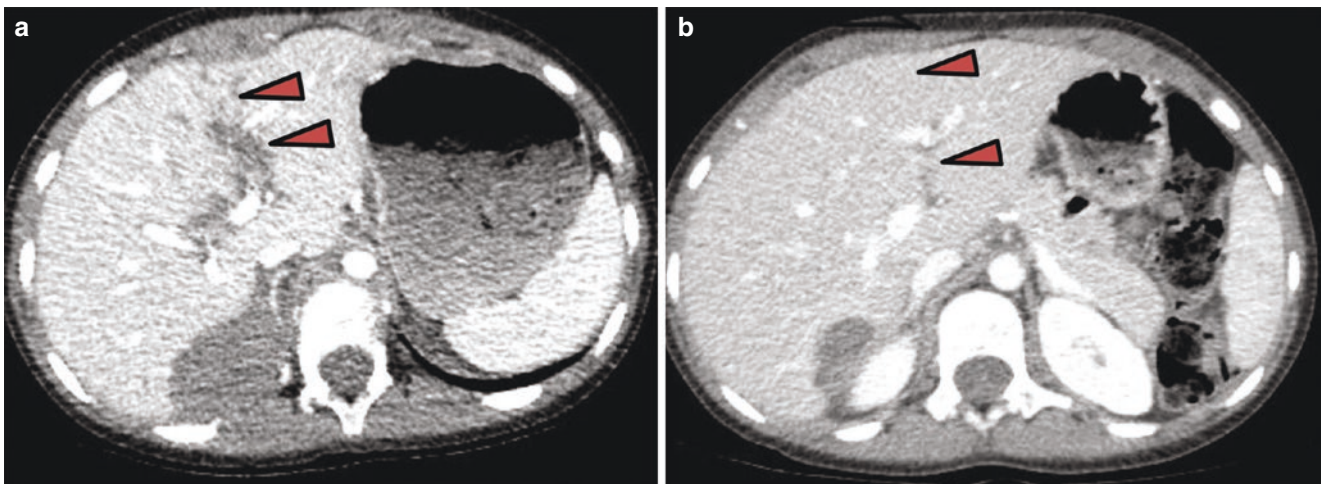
CT scan showing healing fracture. (a) Intravenous contrast enhanced axial scan of the liver in portal venous phase reveals laceration of the segment 4 of liver with right supra renal haemorrhage. (b)
